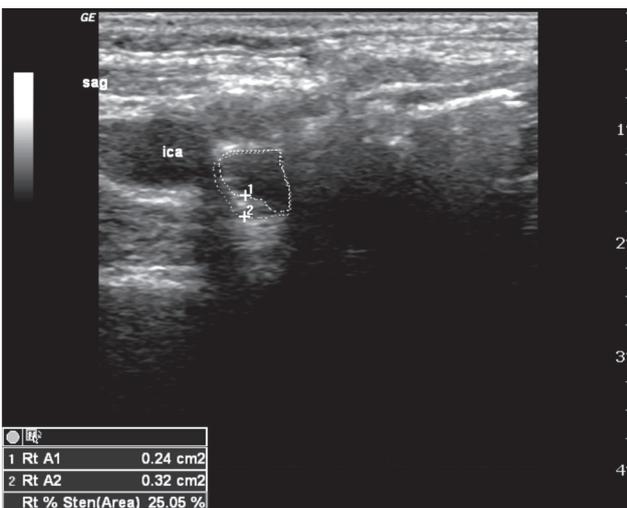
Doppler ultrasound imaging of the right carotid artery of the patient
